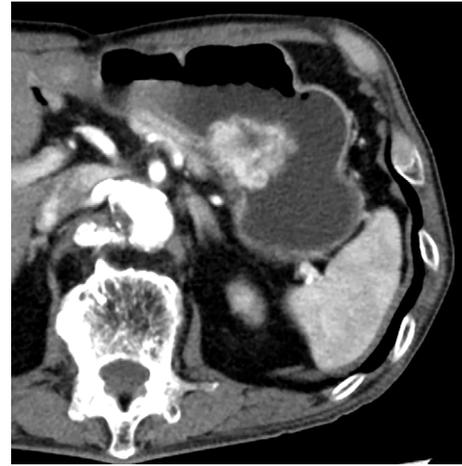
Abdominal contrast-enhanced computed tomography reveals a hypervascular tumor 4 cm in diameter in the posterior gastric wall.
